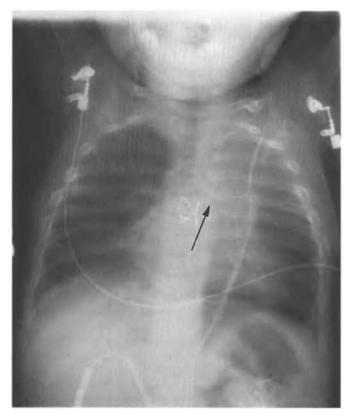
This is a plain portable chest radiograph of a patient immediately following placement of a left bronchial stent. The left upper lobe is atelectatic due to the stent occluding the left upper lobe bronchus. The stent may be faintly seen positioned in the left mainstem bronchus (arrow)
